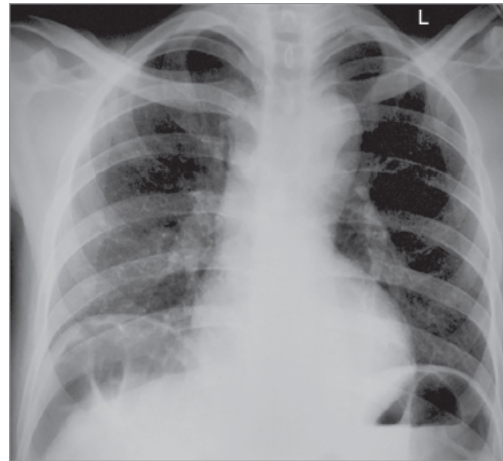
Chest X-ray PA view showing interposition of transverse colon between liver and right hemidiaphragm—Chilaiditi syndrome.
